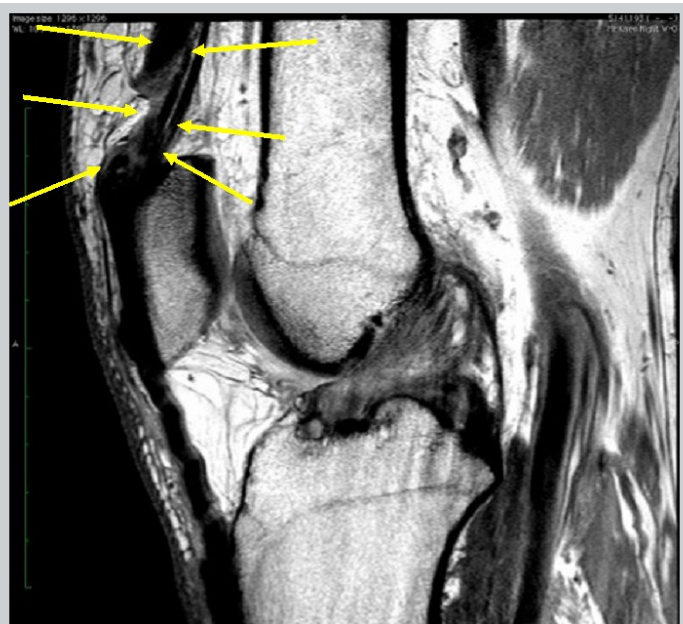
Post-injury MRI w/o contrast showing a portion of the quadriceps complex completely torn. The superficial aspect of the rectus femoris is avulsed from its patellar attachment and retracted proximally. Thinner smaller components of the vastus lateralis, vastus intermedius and vastus medialis remain intact. Arrowheads denote the torn quadriceps complex.
